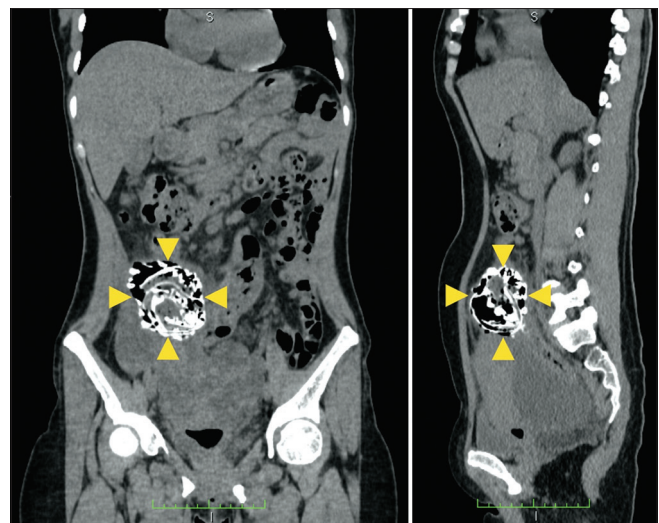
Coronal and sagittal views of the abdominal computed tomography scan detailing the bony fetal head (outlined by yellow arrow heads) seen in the right lower abdominal region described as a contracted fetus with disorganized anatomy
